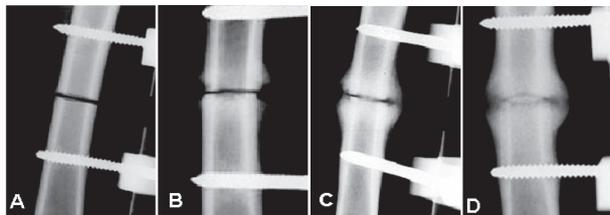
Radiographic controls obtained at the immediate postoperative period (A), and after 30 (B), 45 (C), and 60 days (D), showing union progression.
